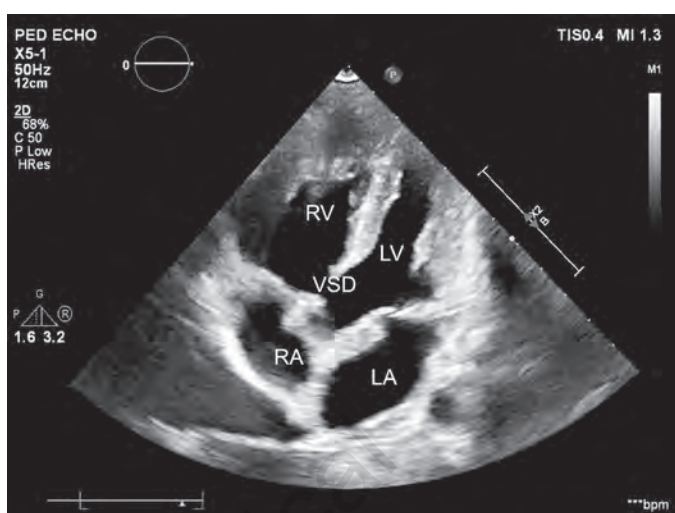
TOF: Apical four-chamber view showing malaligned VSD and aortic override.
